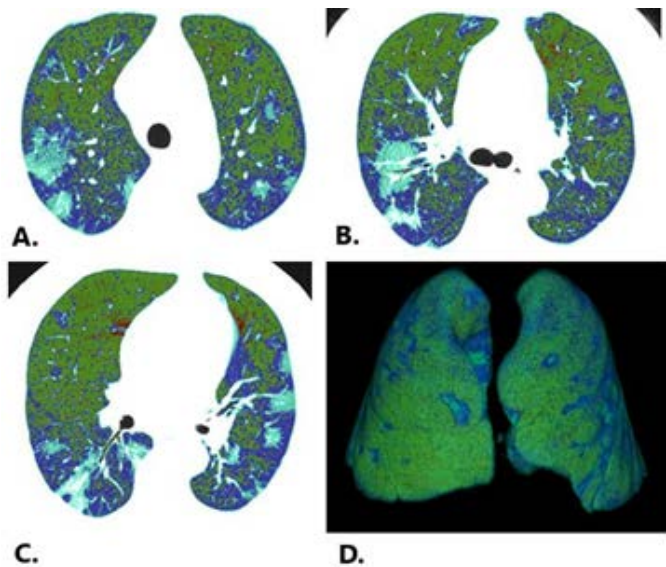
Grade 3: Automated Lung Density Color Mapping. Axial CT images obtained (A) 5 cm above the tracheal bifurcation, (B) at the level of the tracheal bifurcation, and (C) 5 cm below the tracheal bifurcation, with (D) three-dimensional volume rendering. Density-based color classification according to HU intervals: red, emphysema (-1000 to -950 HU); green, hyperinflation (-949 to -850 HU); blue, normal parenchyma (-849 to -700 HU); light blue, hypoventilation/consolidation corresponding to fibrosis-like changes (-699 to -200 HU).
